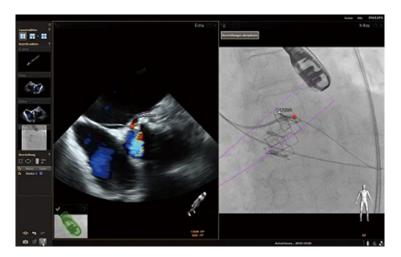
A case of a prosthetic paravalvular leak presenting aortic regurgitation after transcatheter aortic valve repair. The left panel demonstrates the Echo image in a short axis view, presenting the aortic annulus and depicting the regurgitant jet with Color Doppler. Here the marker was placed incorrectly, consequently transfering the marker next to the destination in the fluoroscopic image in the right panel. The red marker demonstrates where the region of interest should have been defined, reflecting the correct position in the fluoroscopic image.
